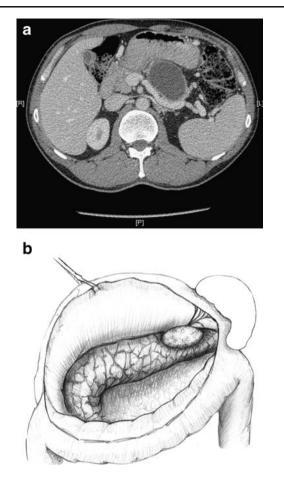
a, b This CT scan section (a) shows a small retrogastric PP that was drained (cystgastrostomy) via an exogastric approach. Division of the gastrocolic omentum (lesser sac approach) readily identifies small retrogastric PPs (b) and facilitates exogastric drainage.
